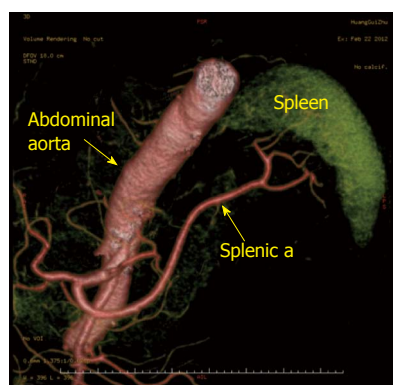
Preoperative computed tomography angiography showing the drainage of the splenic arteries. Abdominal aorta (arrow); splenic a (arrow). a: Artery.
